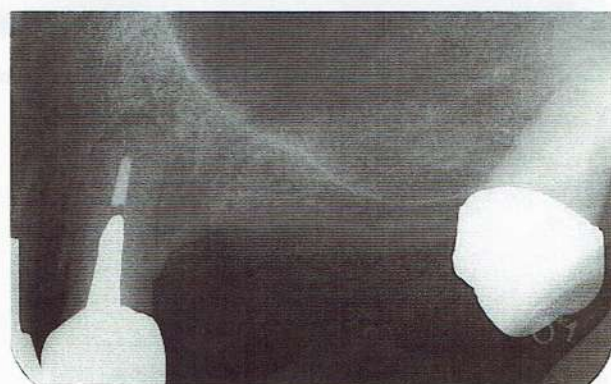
Preoperative radiograph of left first molar
